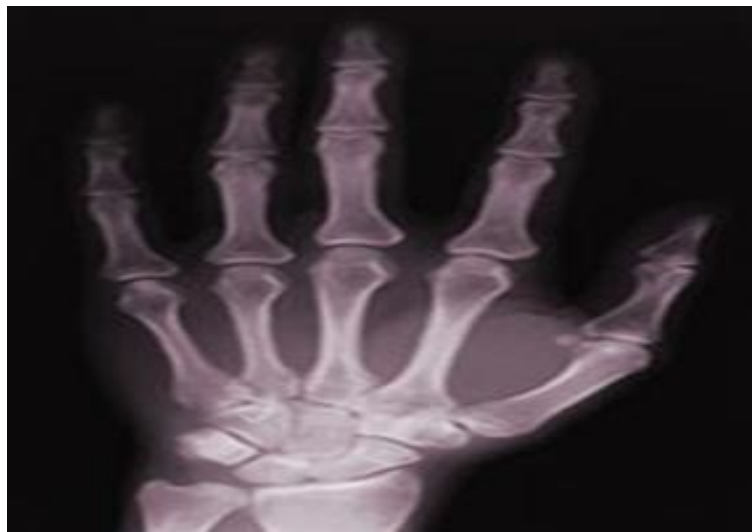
Example of an X-ray (adapted from IEEE GHN)
